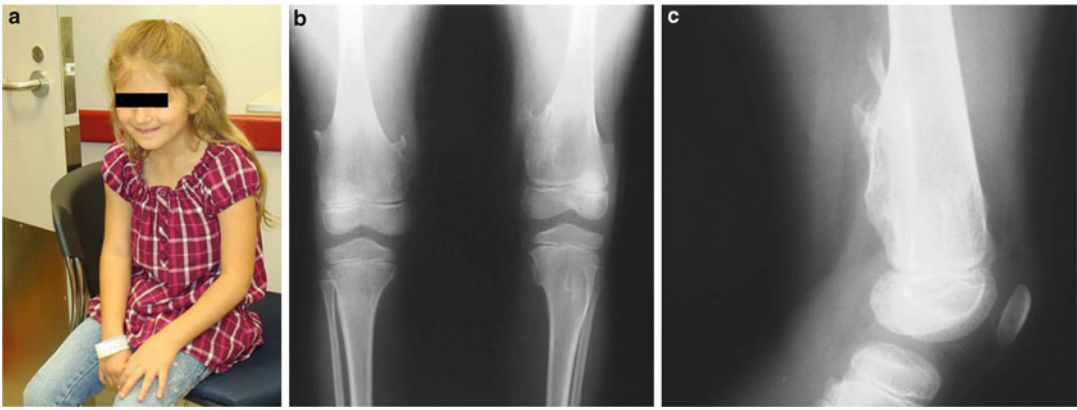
(a–c) A 9-year-old girl (a) with hereditary multiple exostoses showing typical radiographic features of both distal femurs (b)
